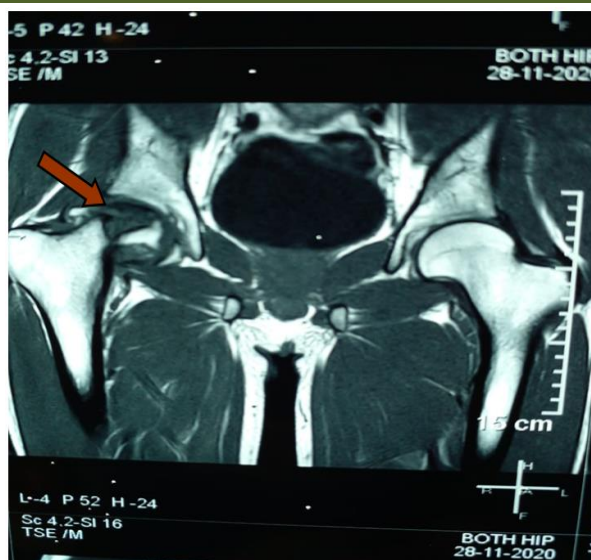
MRI of hip joint showing avascular necrosis (stage iv) at right femoral head with surrounding marrow oedema and features of synovitis with mild effusion
